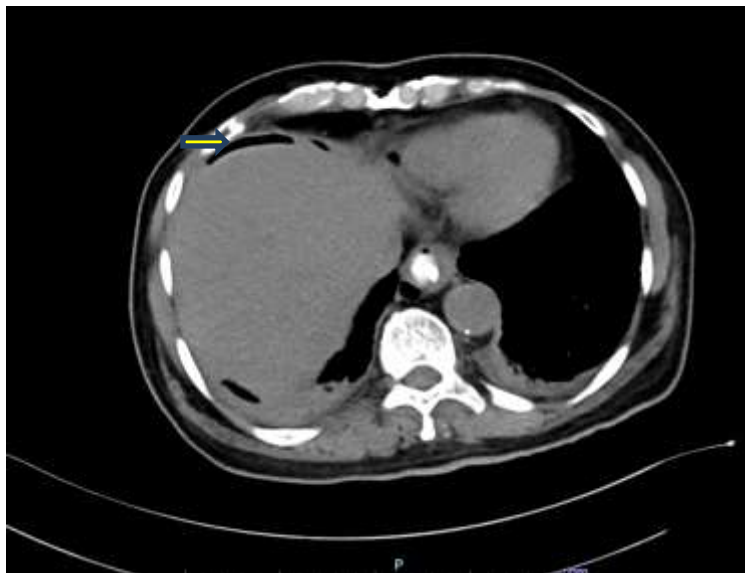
Free intraperitoneal air along superior and anterior surface of liverseen in CT Scan Abdomen dated 28-04-2023.
